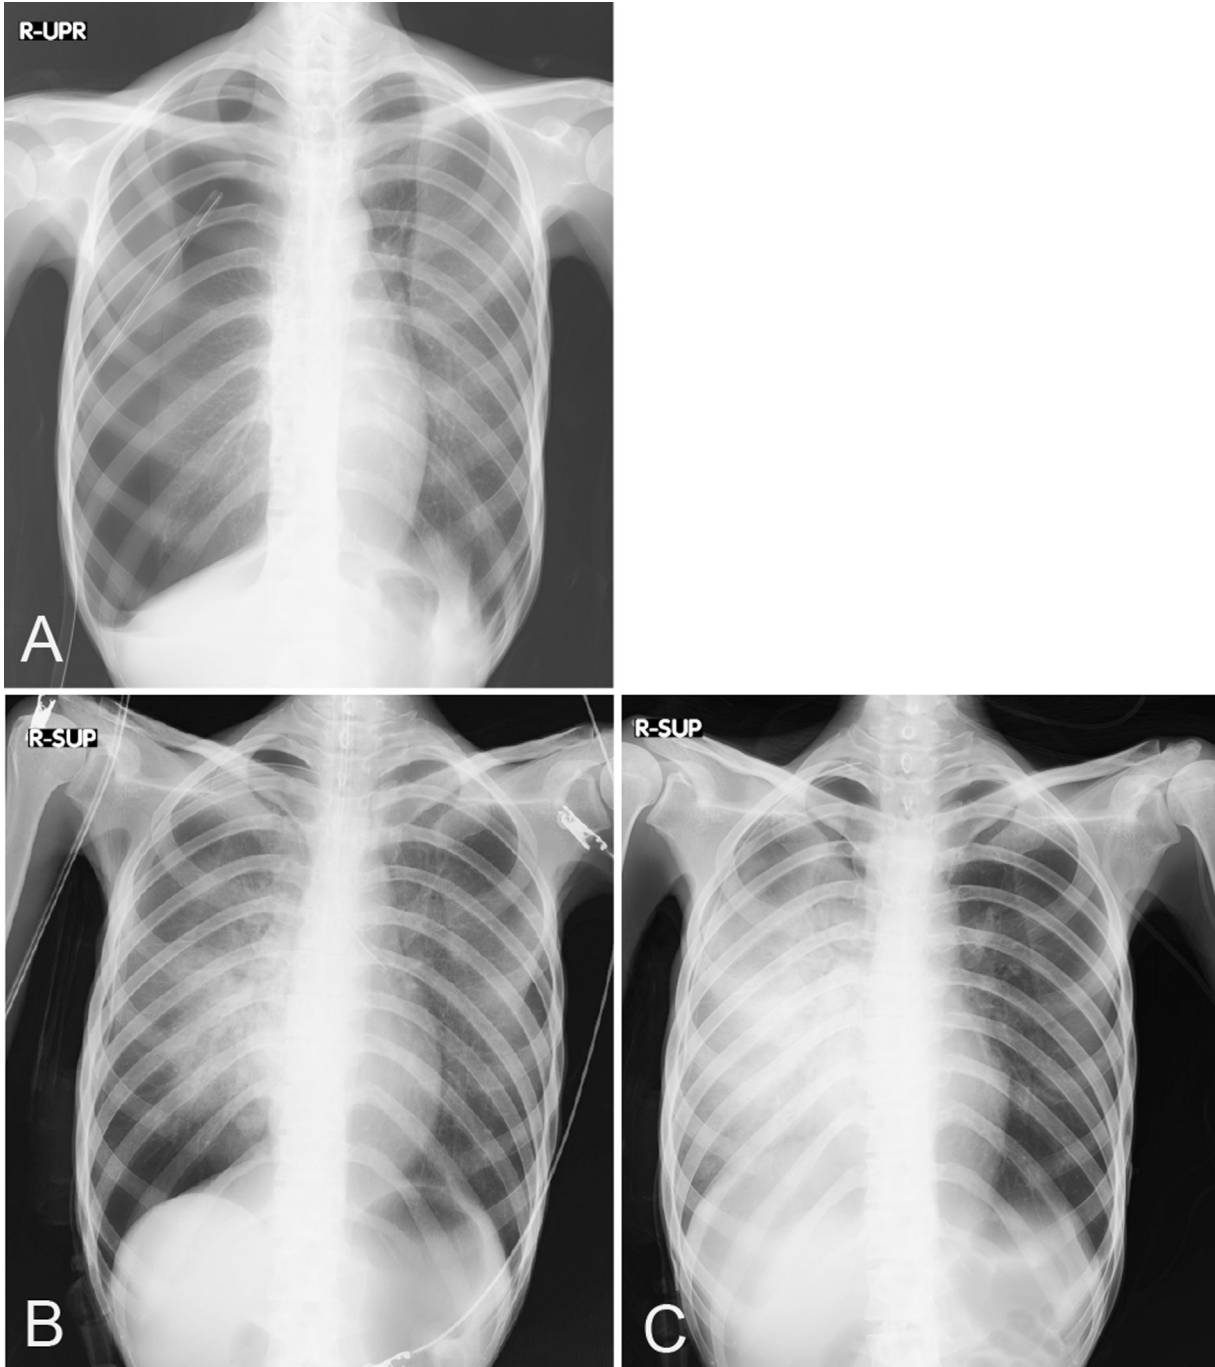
(A) Chest radiograph obtained on admission showing pneumothorax in the right lung, and placement of the chest drain in the right pleural cavity. (B) Chest radiograph before extubation showing early infiltration in the mid zone of the right lung. (C) Chest radiograph 5 hours after extubation showing full-blown right-sided reexpansion pulmonary edema.
